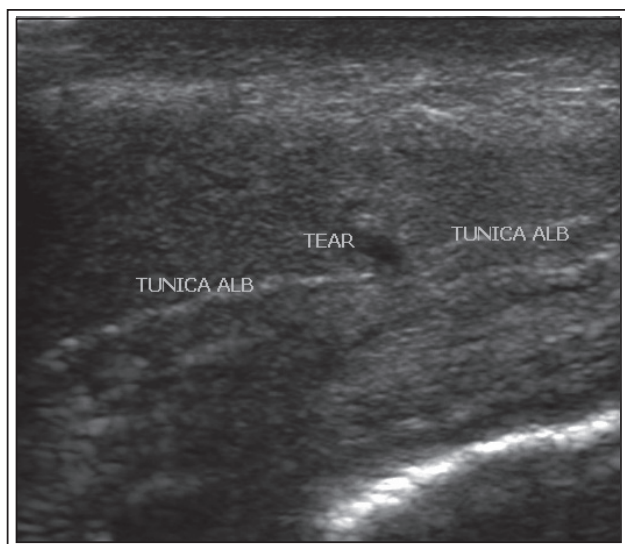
Ultrasonography (USG) scan in a patient with delayed presentation, which shows a tunical tear of the corpus cavernosum.
